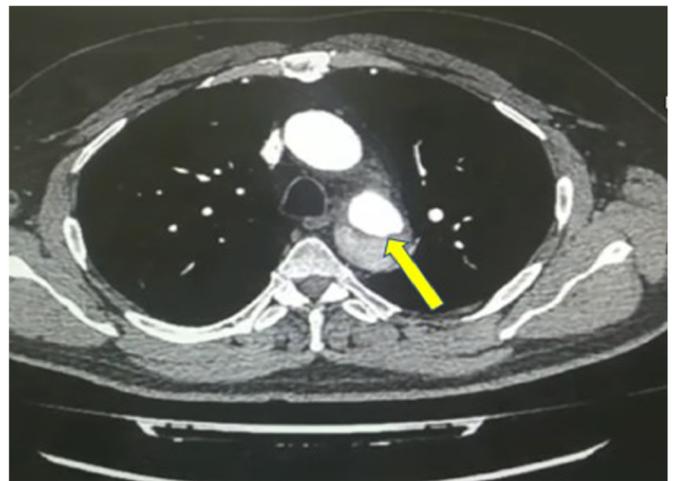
Transverse computed tomography imaging of the thoracic aorta. A yellow arrow points to the intimal flap that is visible within the aorta.
